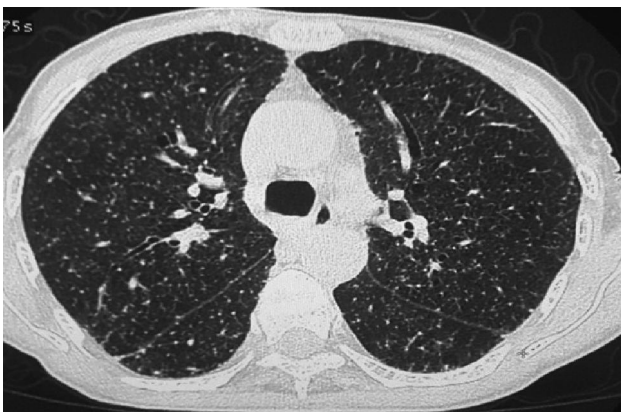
HRCT Chest, lung window, axial section at the level of carina shows bilateral upper and lower lobes of lungs impregnated with numerous tiny discrete nodules in random distribution i.e. along fissures, pleural surfaces, bronchovascular bundles and centrilobular regions, suggesting miliary tuberculosis.
